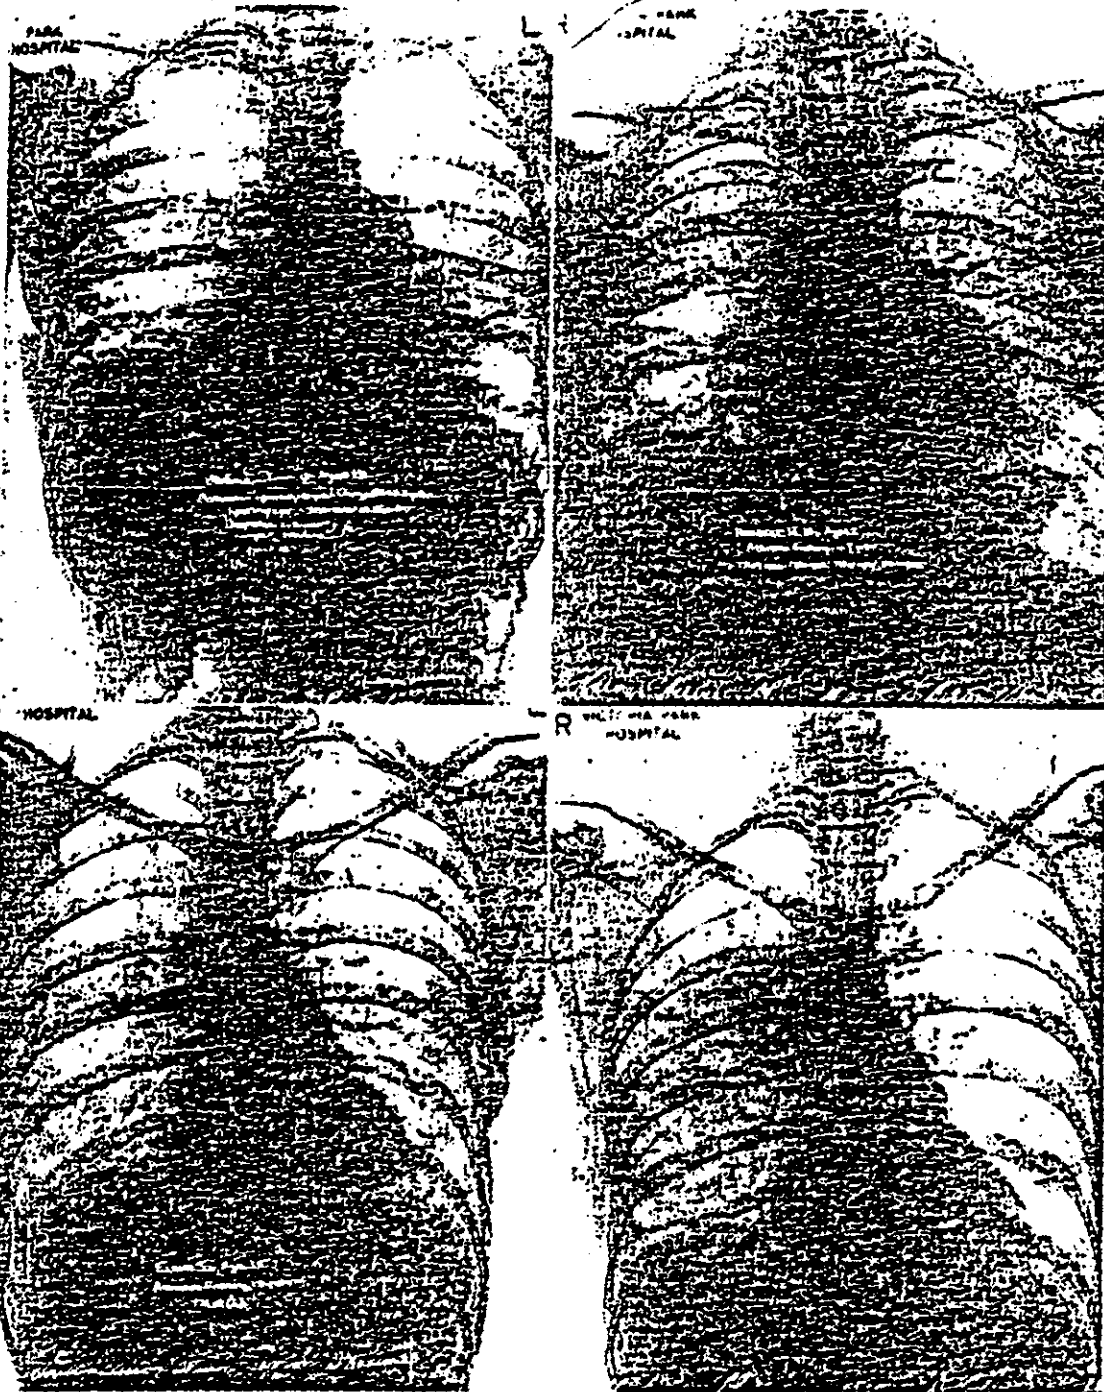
(upper left). Roentgenogram of chest of patient who was an asbestos spinner for twelve years and had symptoms for three years.
